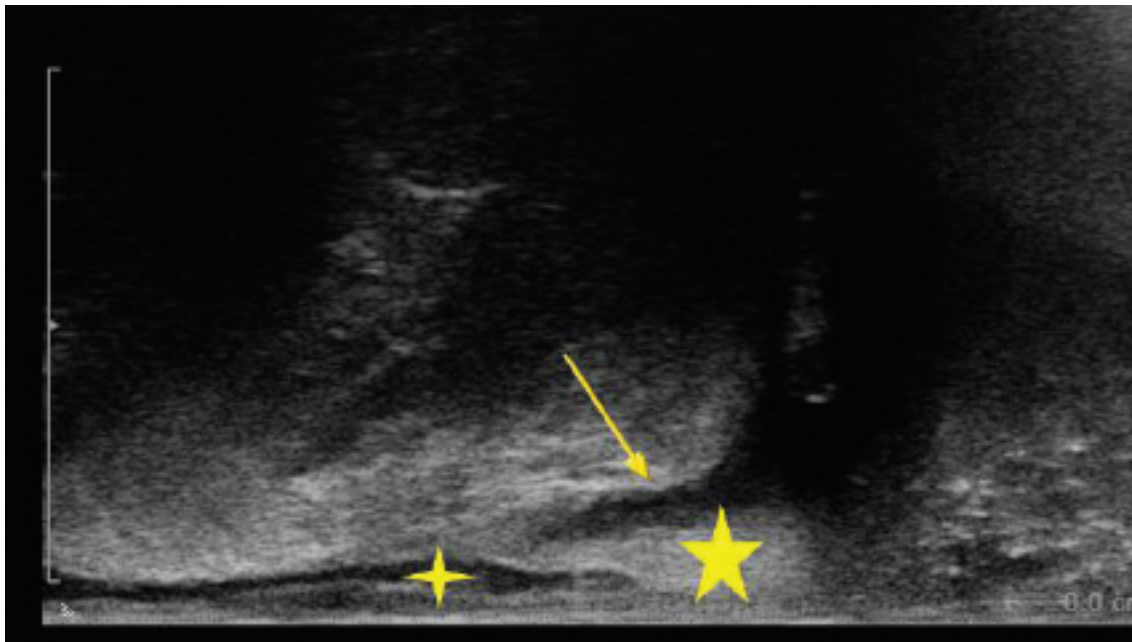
Trans rectal ultrasound examination with linear array, sagittal image showing a trans-sphincteric perianal fistula (arrow) extending from anal canal cranially through the usually echorich external sphincter (large five-pointed star) to skin surface at nates. Small, four-pointed star indicates internal sphincter with its usual echopoor appearance.
